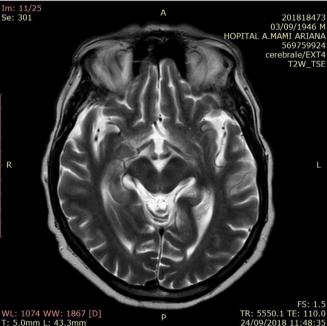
(a) and (b) Cerebral MRI revealing bilateral high signal intensity on T2-weighted and FLAIR image in the hippocampus.
